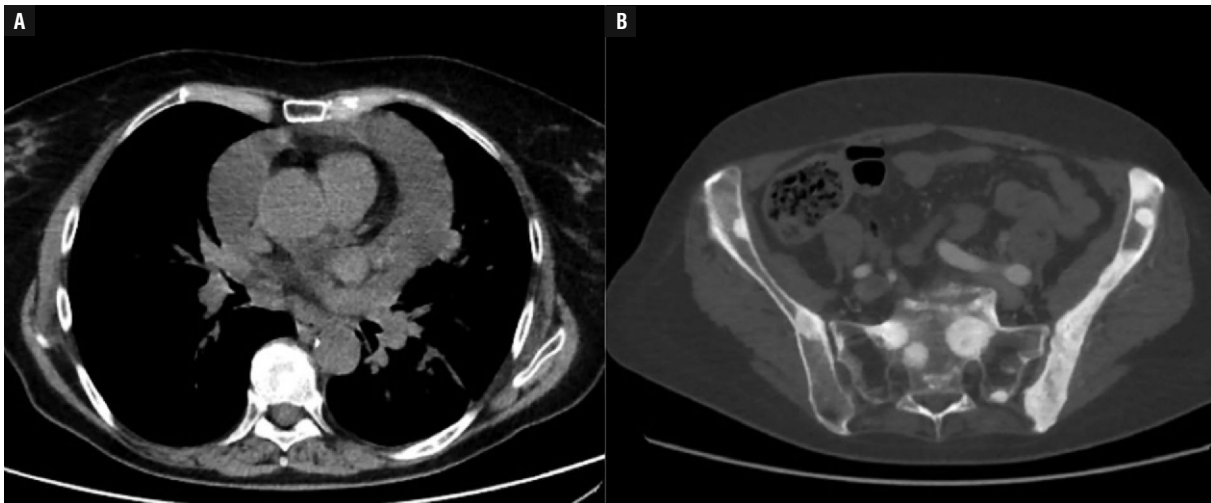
Computed tomography scans presenting pericardial effusion and bone metastasis at the time of diagnosis
